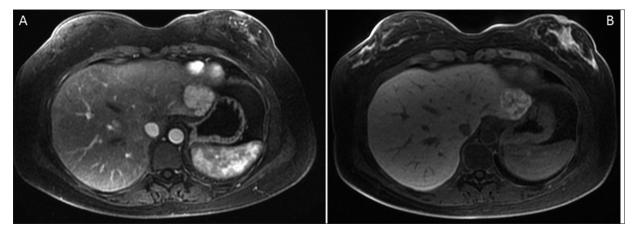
Focal nodular hyperplasia. A, Post contrast axial T1-weighted-fat suppressed acquisition in the arterial phase, shows a hypervascular lesion in the left liver lobe. B, In the hepatobiliary phase the lesion appears hyperintense compared with the background liver with a non-enhancing central scar.
